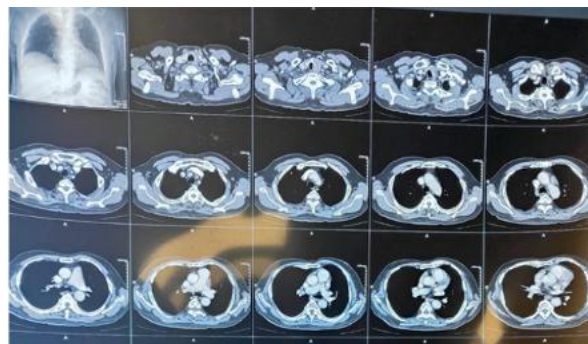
CT neck axial view showing infiltration of the tracheal wall.
